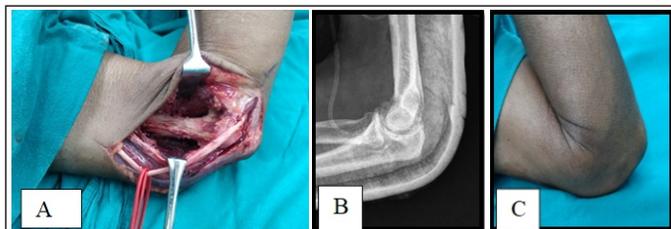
A- Intraoperative picture post excision of tumor. B- Post excision radiograph of elbow. C- Improved range of motion of elbow post operatively.
